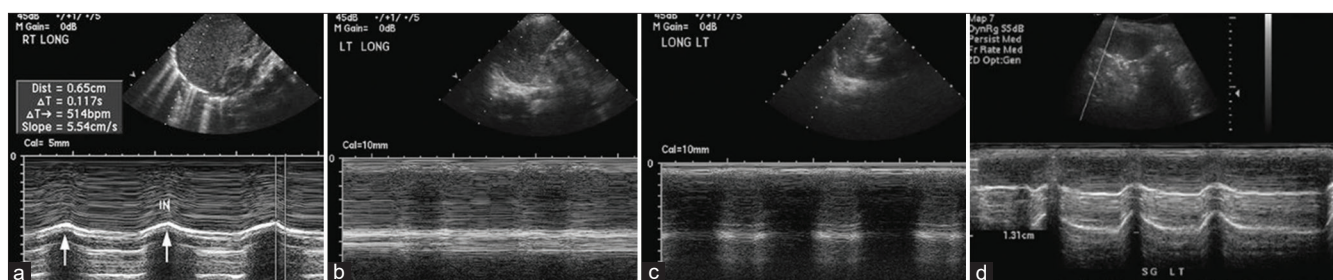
M-mode ultrasound showing initial and follow-up ultrasound in a 4-month-old infant having post-cardiac surgery with left diaphragmatic paralysis. (a) Normal right hemi-diaphragm with inspiratory peak above the baseline. (b) First ultrasound shows a flat line indicative of absent motion of the left hemi-diaphragm. (c) Follow-up ultrasound shows some movement of the left hemi-diaphragm during inspiration. (d) Complete recovery of left diaphragmatic paralysis is seen with return of normal inspiratory peak
